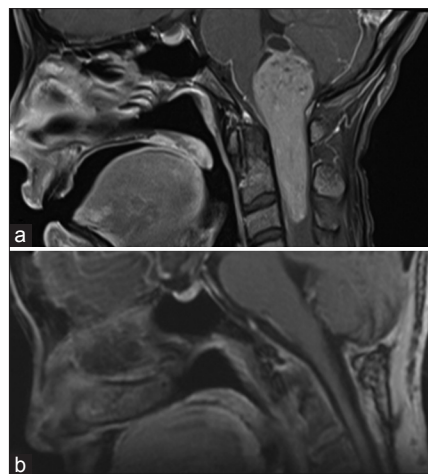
The patient's (a) preoperative and (b) 1-year postoperative sagittal T1-weighted magnetic resonance imaging with gadolinium
